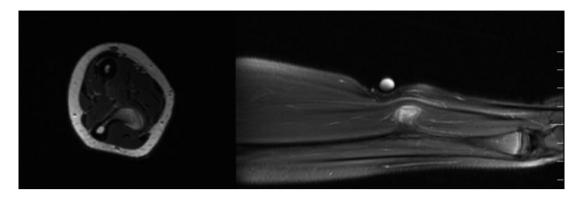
Axial and sagital T2 MRI of the ulnar lesion
